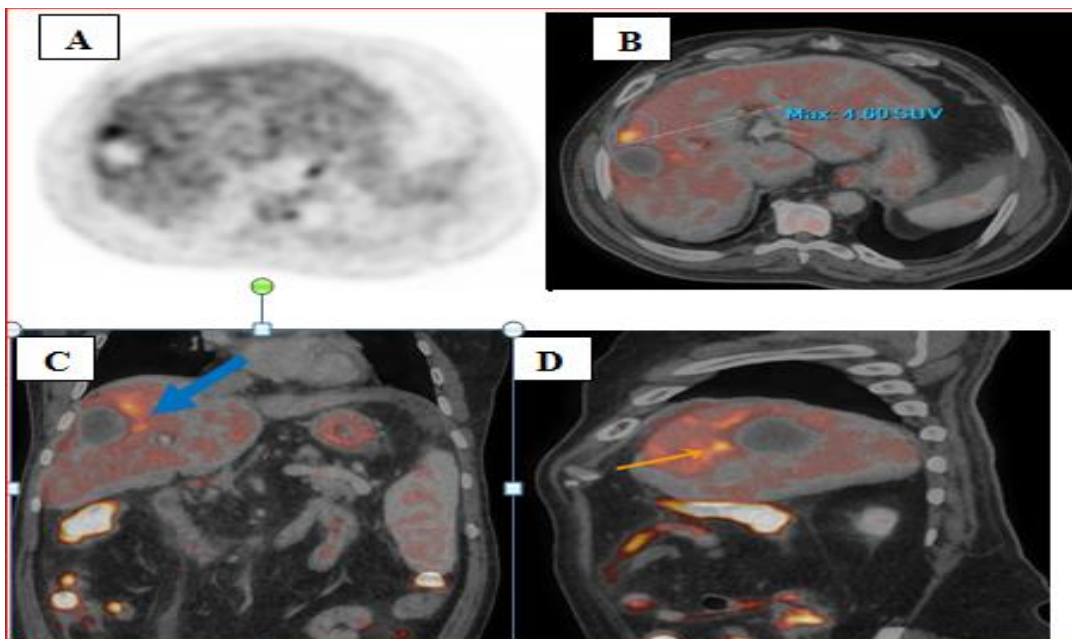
45 years old male patient with history of HCC diagnosed with typical enhancement criteria of HCC by triphasic CT and elevated alpha fetoprotein (144 ng/ml) underwent radiofrequency ablation and referred for PETCT I month later after RFA.
